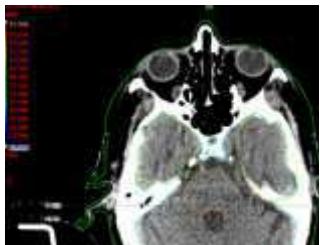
Trigeminal neuralgia target volume (right and left) and Isodose distribution on CT and MRI axial section
